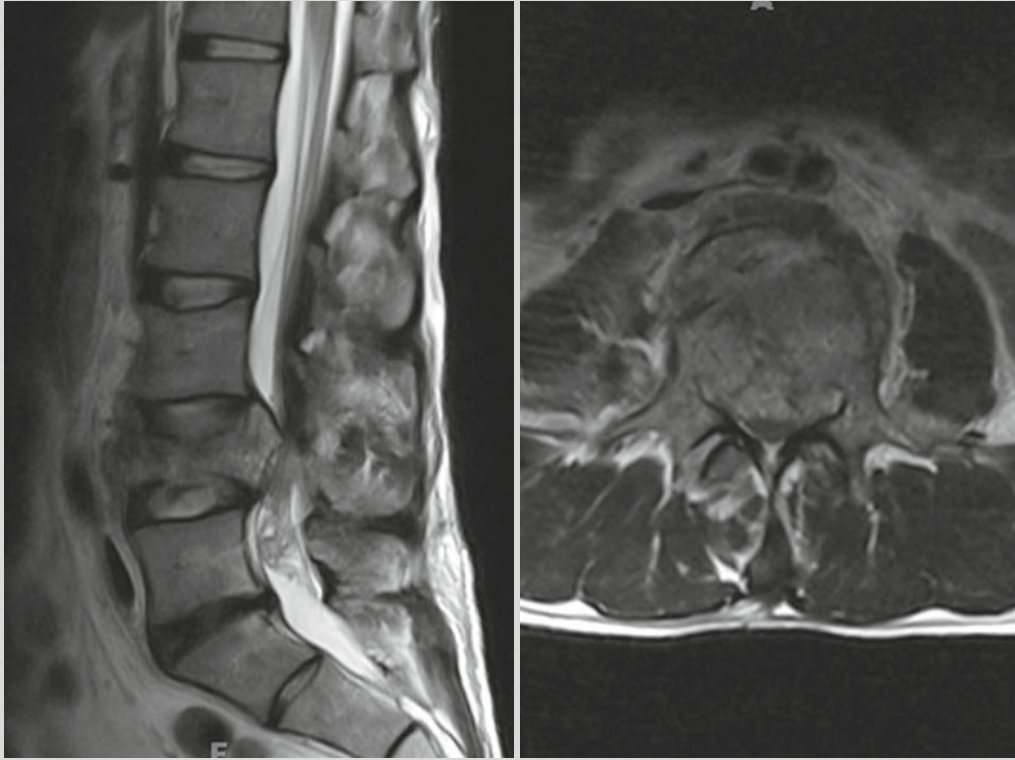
T2-weighted MRI midsagittal and L4 axial images showing burst fracture fragment retropulsion and complete obliteration of the spinal canal. Notice the redundancy of the nerve rootlets indicating severe stenosis
